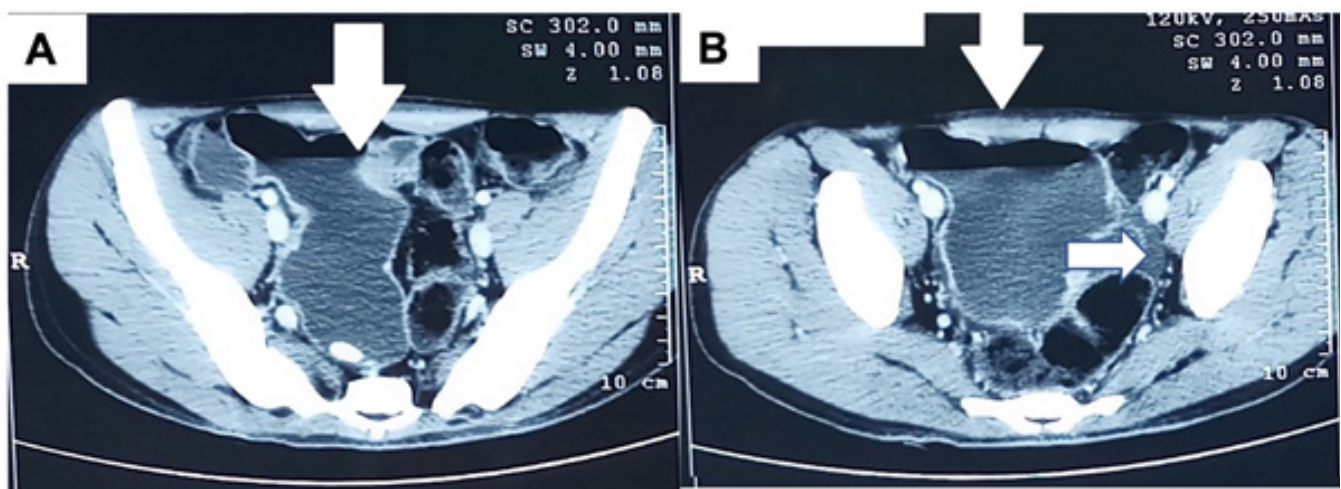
Contrast enhanced CT scan. A & B - showing dilated bowel loop in pelvis (vertical arrow), B- ascites (horizontal arrow).
